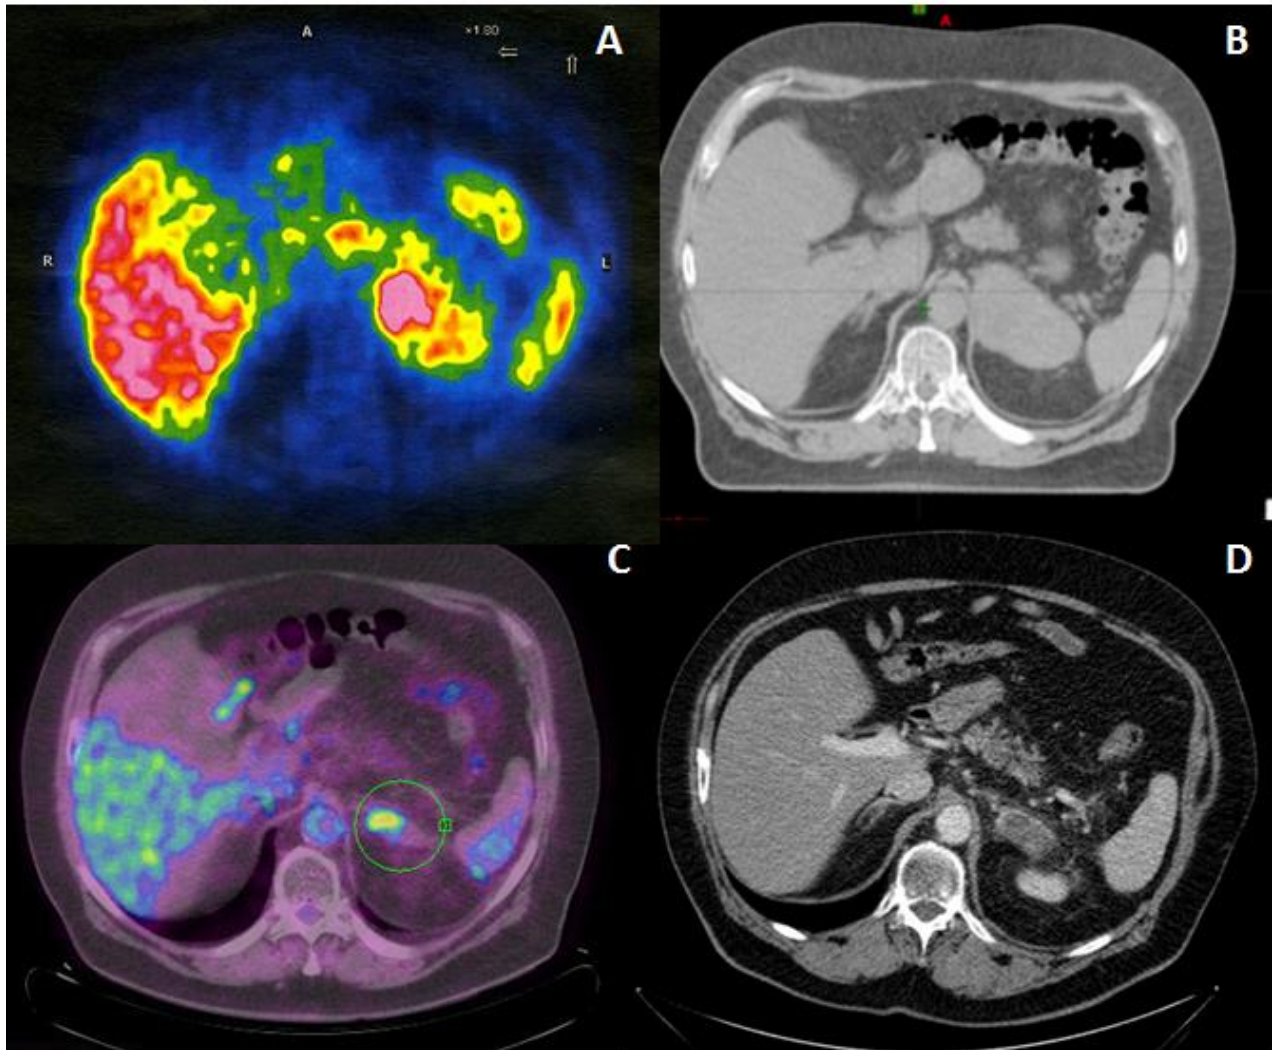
A) choline PET (A) and CT scan (B) performed before radiotherapy, showing an enhancing left adrenocortical mass of 9 cm. C) choline PET performed 3 months after radiotherapy. D) CT scan performed 6 months after treatment.
